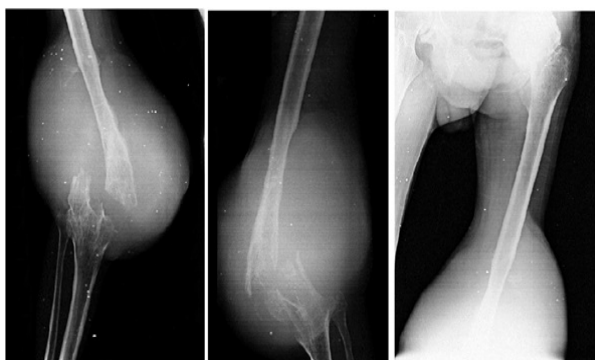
Xrays R) knee AP view, Xrays R) knee lat view, Xrays R) hip + femur AP view
